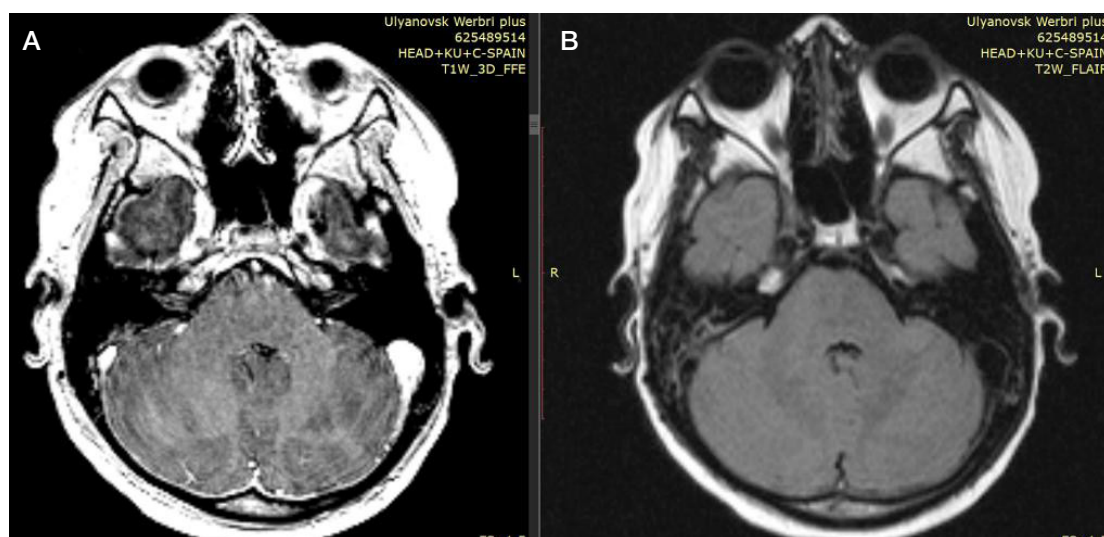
Axial MRI images 1.5 months after RT completion (October 31, 2019): T1W (A) and T2W FLAIR (B)
